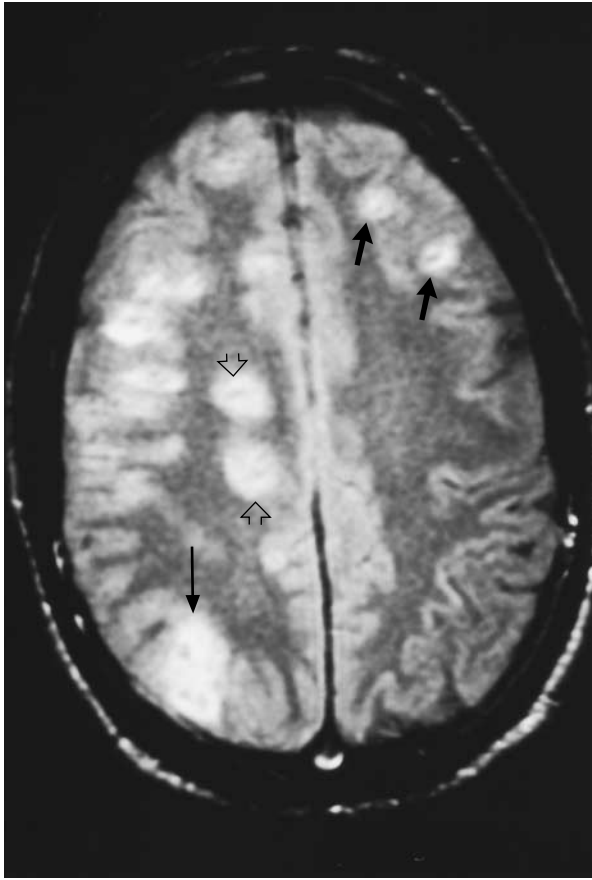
Magnetic Resonance Image of the Brain of a Patient with Varicella–Zoster Viral Encephalitis, or Small-Vessel Vasculopathy.
